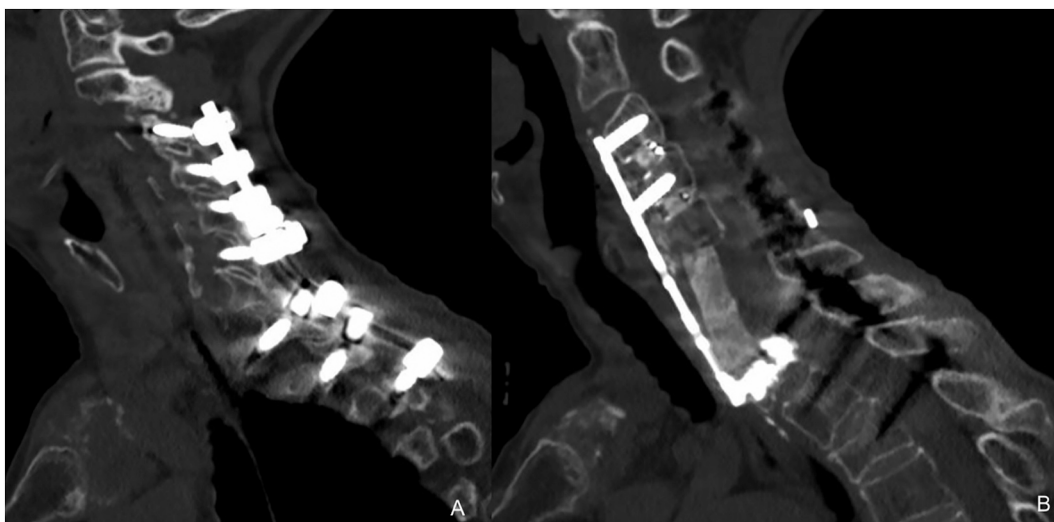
Post-operative CT scan of CAPDF consisting of Posterior Spinal Fusion Revision (A) and C3-C6 ACDF (B).
